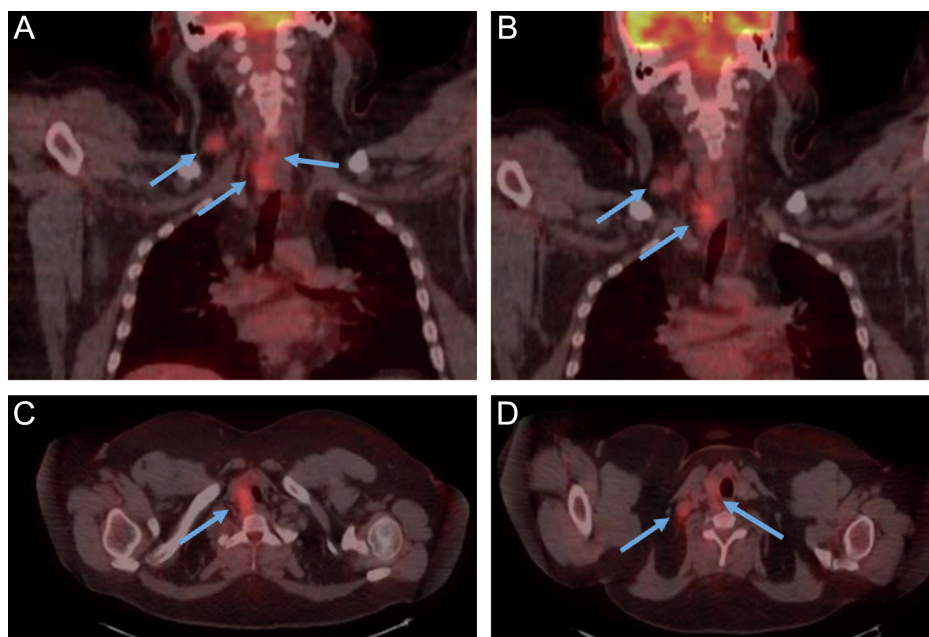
PET CT images in the diagnostic evaluation of the patient. Pathological involvement was observed in the right thyroid lobe (SUVmax : 4.62), right levels 3 and 4, and right level 6. (A, B) Coronal image. (C, D) Transverse image.
